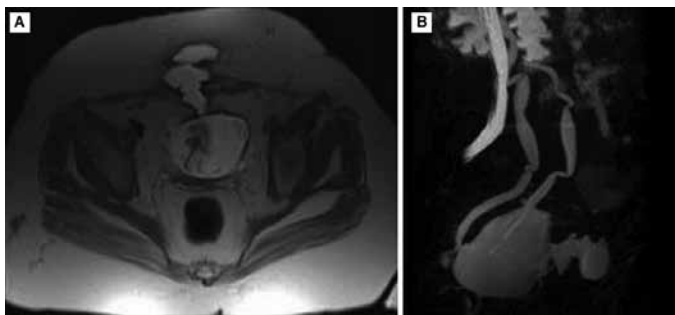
A: T2 Weighted image of the vesico-cutaneous fistula. B: Reconstructed lateral-oblique magnetic resonance image. Fistula tract is clearly seen
